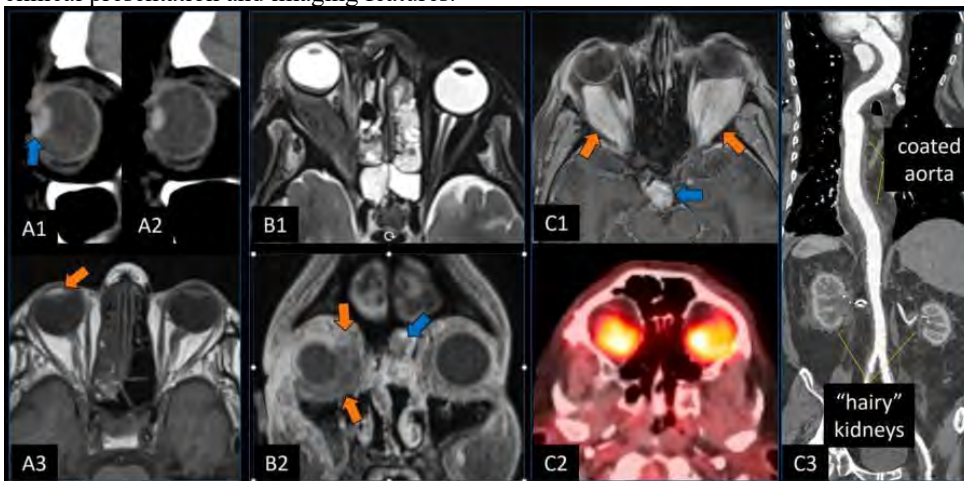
Different patients with various causes of orbital pain. Panel A: CT in a patient with orbital trauma demonstrates hyperdensity in the anterior chamber consistent with hyphema (A1, blue arrow), also seen as T1 hyperintensity on MRI (A3, orange arrow). Compare with normal contralateral globe (A2). Panel B: Axial T2 (B1) and coronal CET1 (B2) in acute invasive fungal infection show extensive inflammatory change in the right orbit with sites of nonenhancement (orange arrows) along with areas of nonenhancing mucosa ("black turbinate" sign, blue arrow). Panel C: CET1 shows sellar (blue arrow) and orbital (orange arrows) masses in a patient with Erdheim-Chester disease. Note avid FDG uptake (C2) as well as typical periaortic and perirenal infiltration on CT (C3).
